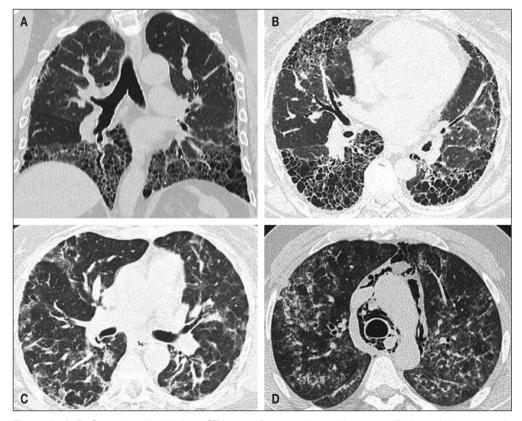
A, B: Coronal and axial chest CT images from a patient with nonspecific interstitial pneumonia associated with polymyositis show subpleural and bibasilar predominant honeycombing changes, and traction bronchiectasis, with discrete areas of ground-glass opacities; C: Axial chest CT image from a patient with polymyositis and acute interstitial pneumonia demonstrates diffuse areas of ground-glass opacities and consolidations; D: Axial chest CT image from a patient with dermatomyositis demonstrates a pneumomediastinum and diffuse areas of ground-glass opacities and consolidations compatible with acute interstitial pneumonia.
